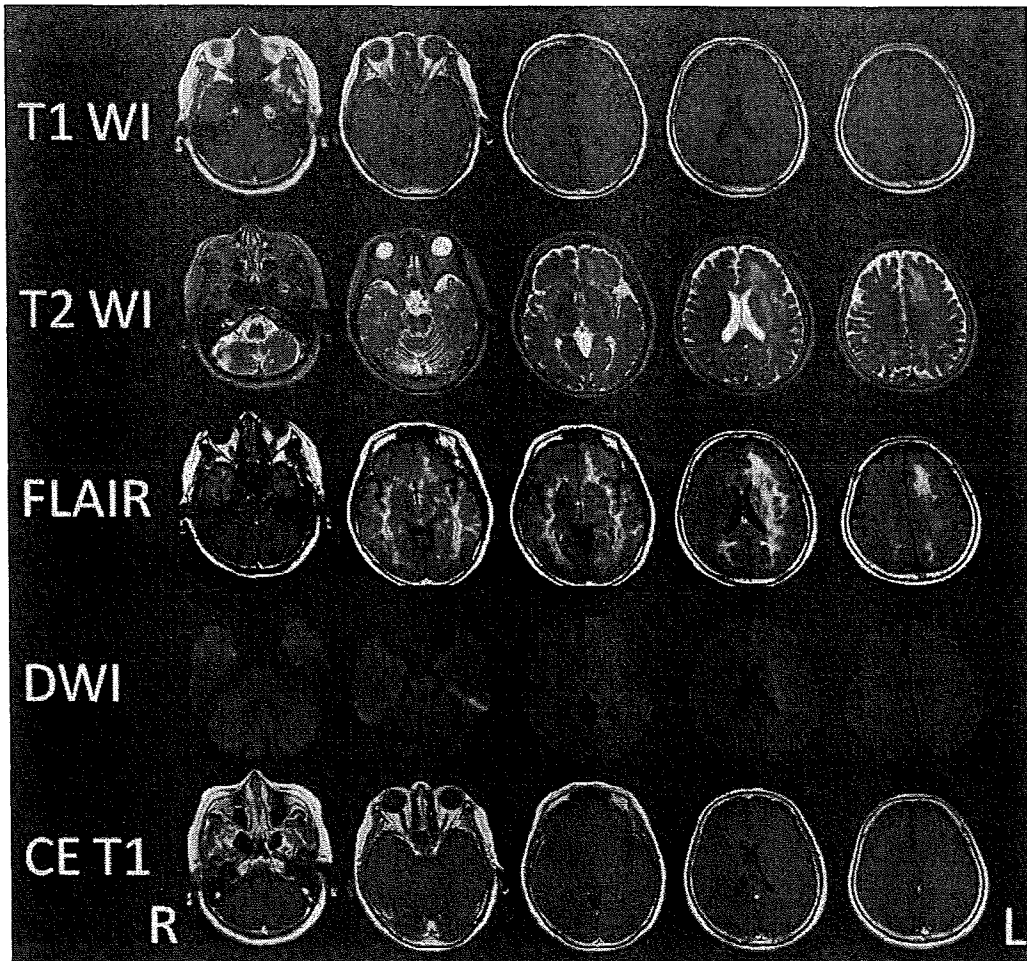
Brain MRI at the time of the admission. MRI disclosed high intensity dissemination throughout the white matter which spread widely from the temporal tip to the pars opercularis on T2WI and FLAIR. In accordance with the high intensity lesions on T2WI and FLAIR, slightly low intensity lesions were found on T1WI. There was no high intensity lesion on DWI except for T2 “shine-through” lesions of the left corona radiata. There was no mass effect or contrast enhancement lesion on contrast-enhanced T1WI.
